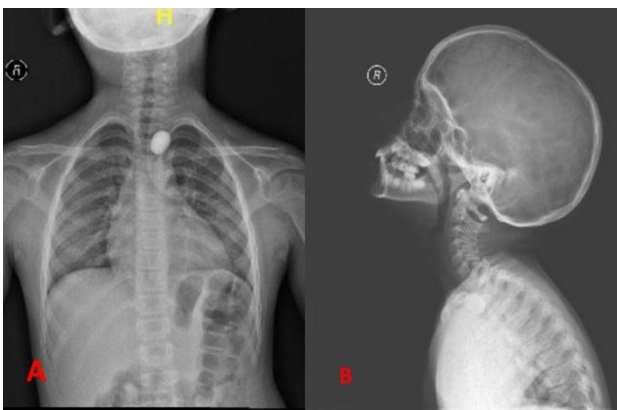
(A) X-ray soft tissue neck AP view; (B) Lateral view showing radiopaque oval shaped foreign body (marble) in esophagus at T1 level.
